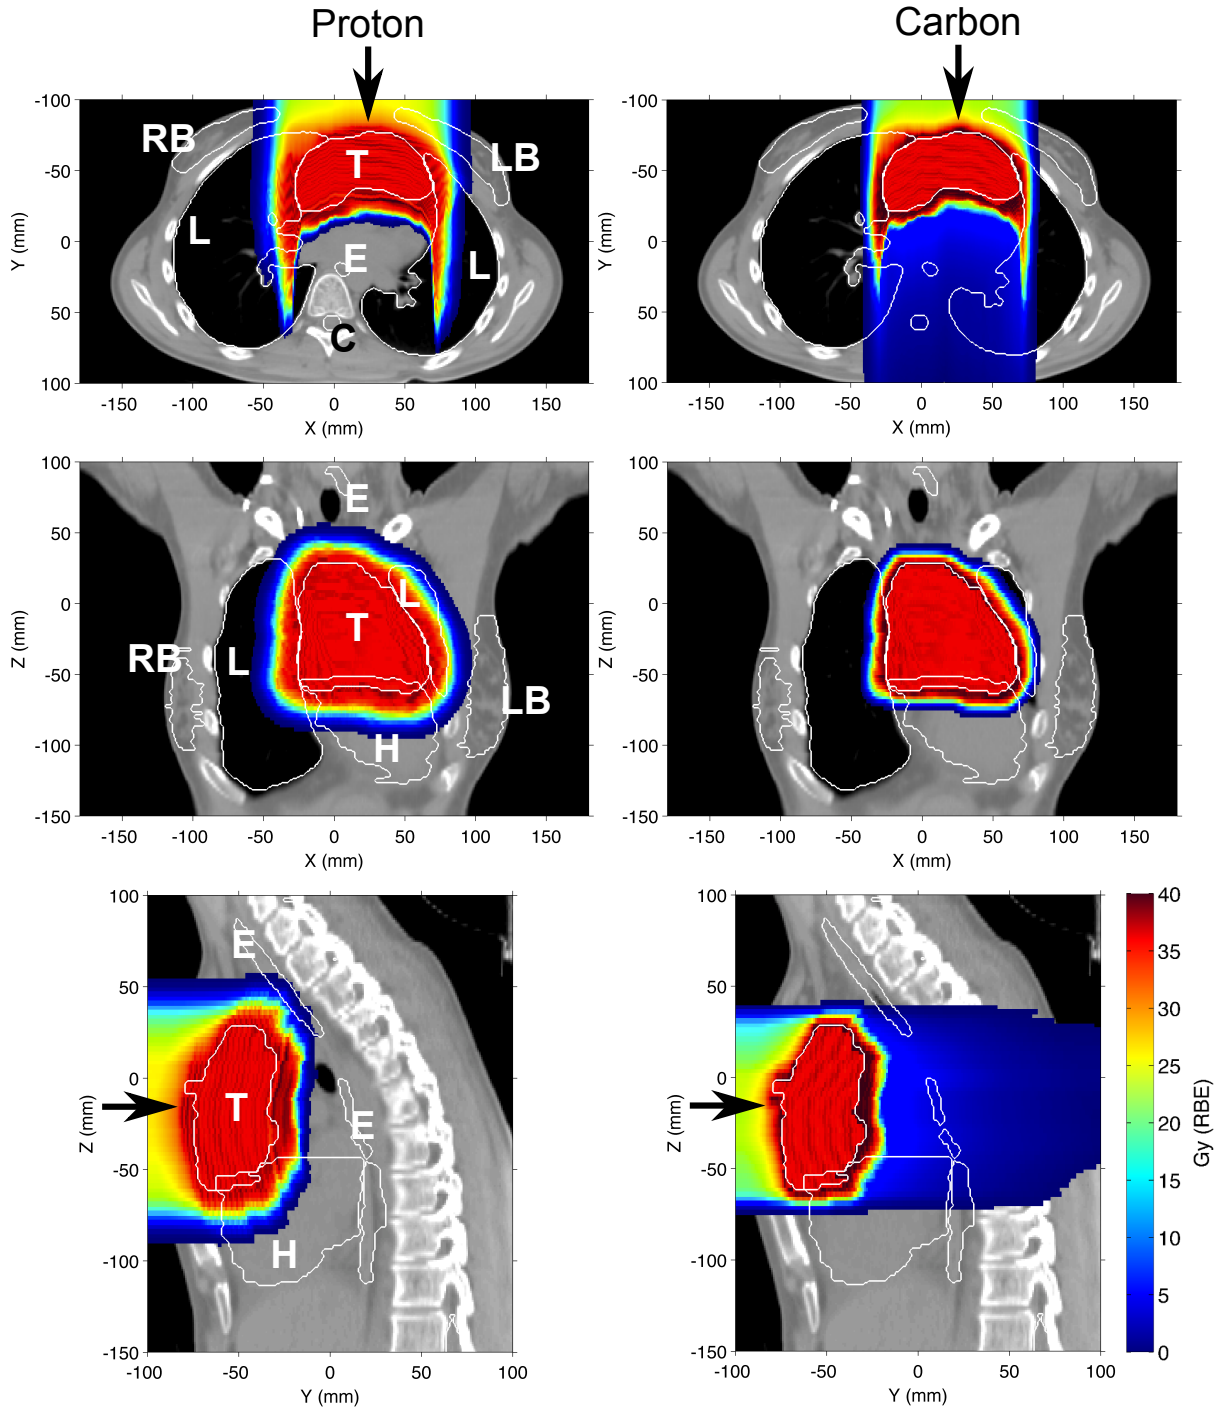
Scanned proton (left) and scanned carbon ion (right) treatment plans for HL Patient #1. RBE-weighted dose colorwash is shown overlaying axial (top), coronal (middle), and sagittal (bottom) CT slices. Contours (white lines) are shown for the CTV (T), right breast (RB), left breast (LB), lung (L), esophagus (E), spinal cord (C), and heart (H). RBE-weighted dose was calculated using one RBE table for HL tumor sterilization inside the CTV ($\alpha/\beta = 8$ Gy) and another RBE table for breast cell sterilization for all tissues outside the CTV ($\alpha/\beta = 3$ Gy). The prescribed CTV RBE-weighted dose was 36 Gy (RBE). Note the lower RBE-weighted dose, *i.e.*, RBE_S , in the left breast seen for the carbon plan compared with the proton plan.
